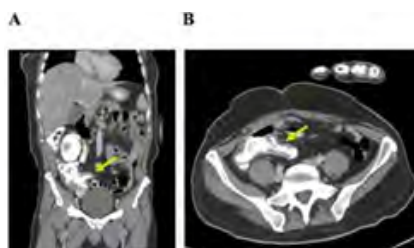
a: The distal/terminal ileum and cecum demonstrated wall thickening consistent with enteritis/colitis on the initial abdominal CT scan. b: Distal/terminal ileal wall thickening can be seen on axial CT imaging.
